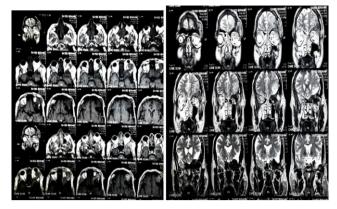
Preoperative MRI showing It sphenoid wing meningioma
